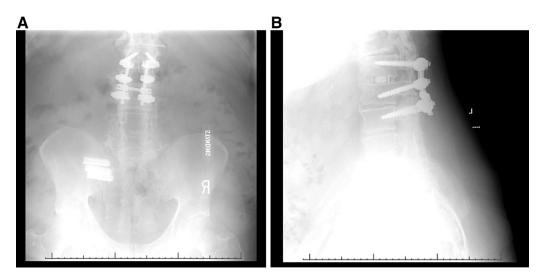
A, 5B Pre-operative AP (5A) and Lateral (5B) view radiographs demonstrating intact hardware with disc space collapse at T12-L1.
